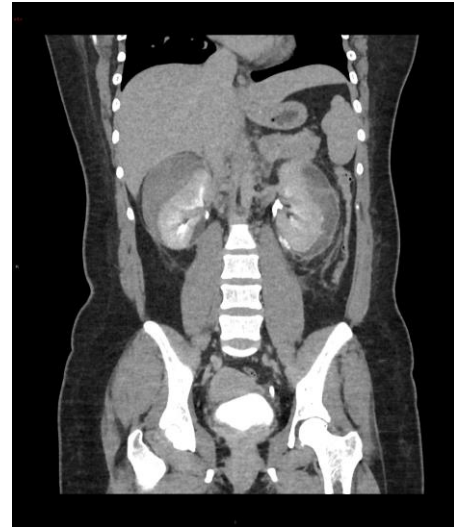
CT after contrast agent administration on late excretory phase, on coronal plane. CT scans show multiple bilateral contrast agent blushes into the hematomas, diagnosed as multiple bilateral active bleedings.
